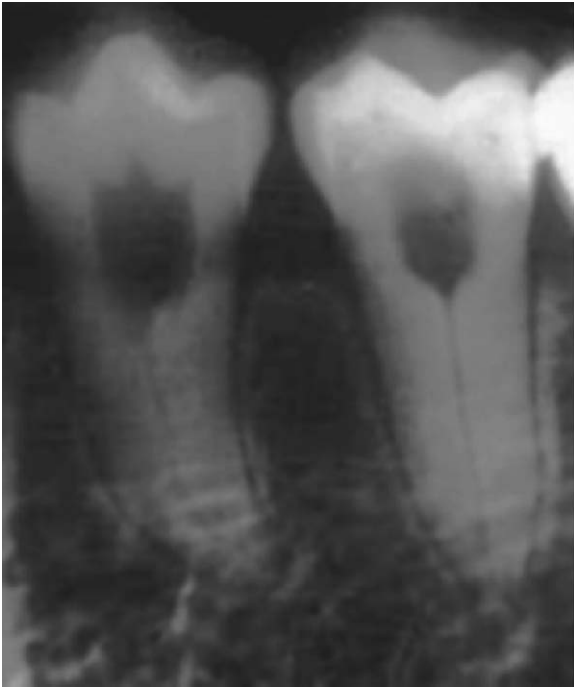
Coronal (Type II) dentin dysplasia. The permanent teeth radiographically demonstrate apical extension of the pulp chamber producing a thistle-tube or flame shape
